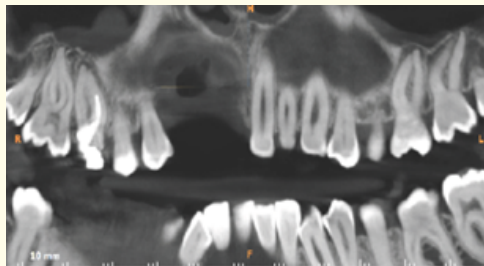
X-ray shows the bone loss.
